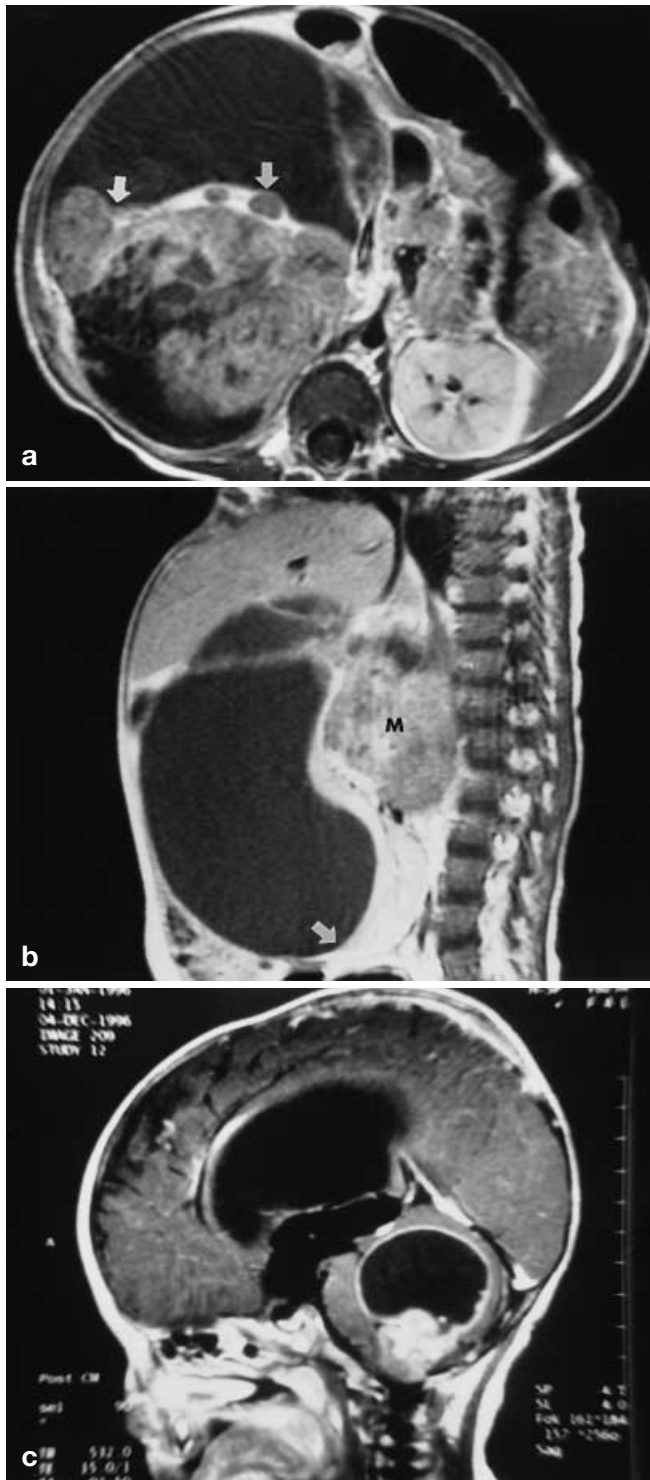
A rhabdoid tumour with lobulated surface in an 8-month-old boy. a Axial T1-W MRI shows the large mass, which is hypointense to normal left kidney, with lobulated surfaces (*white arrows*). Note also the large subcapsular haematoma. b Sagittal, T1-W gadolinium-enhanced MRI shows a poorly contrast-enhanced mass (*M*) in the upper pole of the right kidney. Note the large subcapsular haematoma and stretched renal parenchyma (*white arrow*). c Sagittal, T1-W gadolinium-enhanced MRI of the brain shows a midline, posterior fossa cystic mass with an intensely enhancing solid portion
